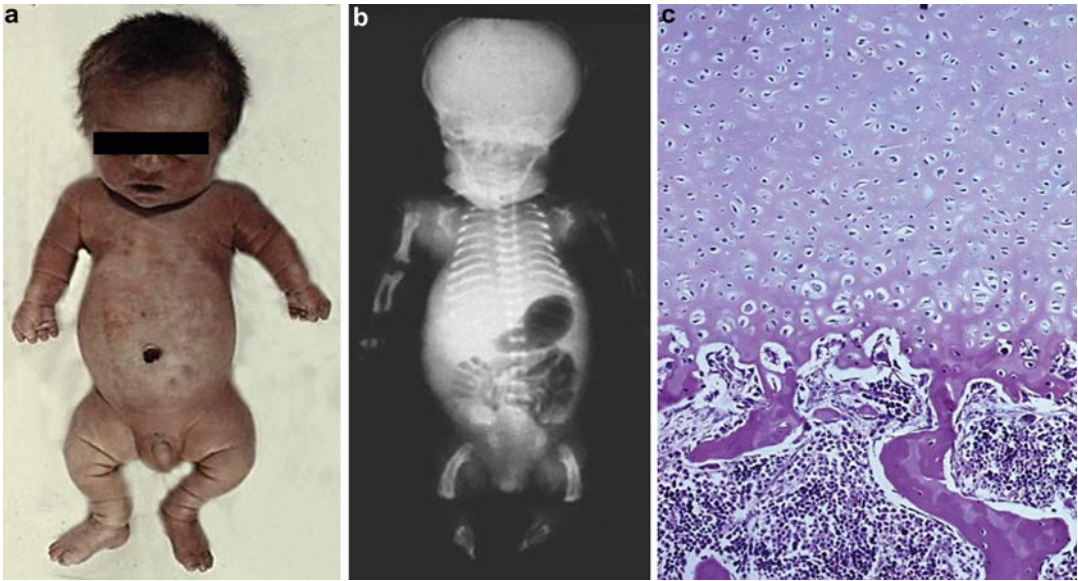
Homozygous achondroplasia. Both parents are achondroplastic. The large head, narrow chest, and severe rhizomelic shortening of the limbs are similar to those of thanatophoric dysplasia (a). Radiograph (b) shows severe platyspondyly, small ilia, and short limb bones.
